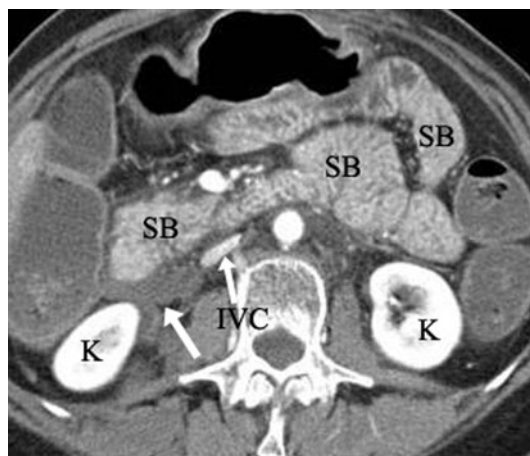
A 58-year-old male status post-blunt abdominal trauma. Axial contrast-enhanced CT of the abdomen demonstrated loops of small bowel (SB) with pronounced mucosal enhancement. A small amount of free fluid (arrow), flattened inferior vena cava (IVC) and increased enhancement of kidneys (K) were noted. Findings are consistent with shock bowel secondary to hypotension. Chart review confirmed that the patient had cervical spine injury without bowel injury.
